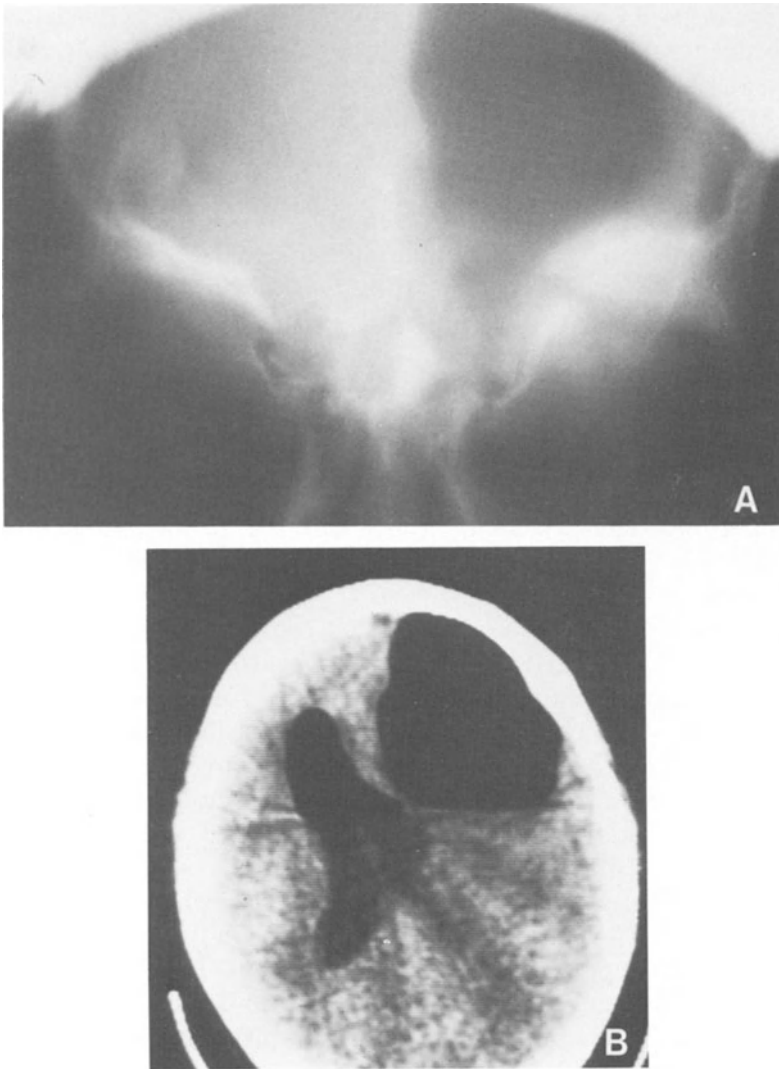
Traumatic space-occupying arocele 7 years after the trauma.* A) Polytomographic a.-p. view. The large contusional defect of brain substance in the left frontal lobe is filled with air. A compound fracture of the fronto-ethmoidal region, including the orbital roof, is clearly visible. B) CT of the same case. The ventricles are partly filled with air. The shift to the right side indicates that the large pneumatocele within the left frontal lobe acts as a space-occupying lesion
